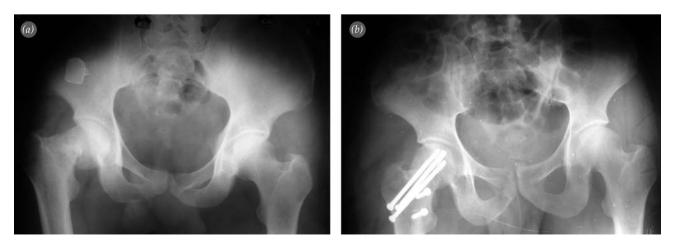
(a) Radiograph of 42-year-old patient presented 4 months after the injury. (b) Two-year follow-up radiograph of the patient with bony union and absence of avascular necrosis.
